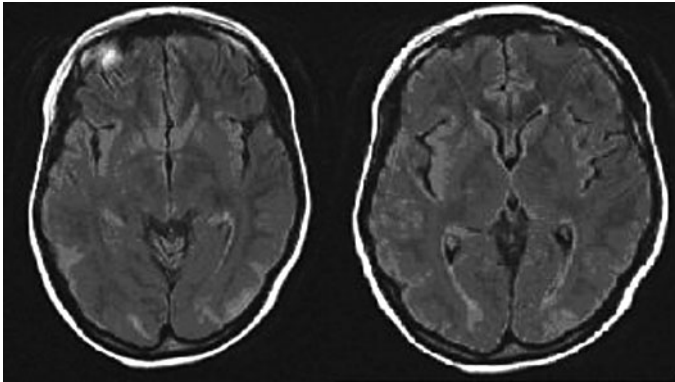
Brain MRI showing a reduction of the subcortical edema.
